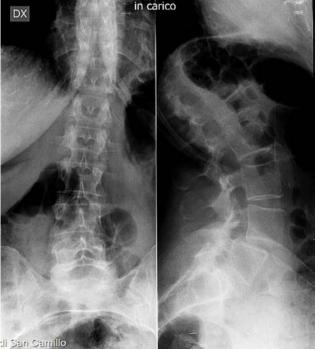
Preoperative frontal and lateral standing lumbosacral spine X-ray.
